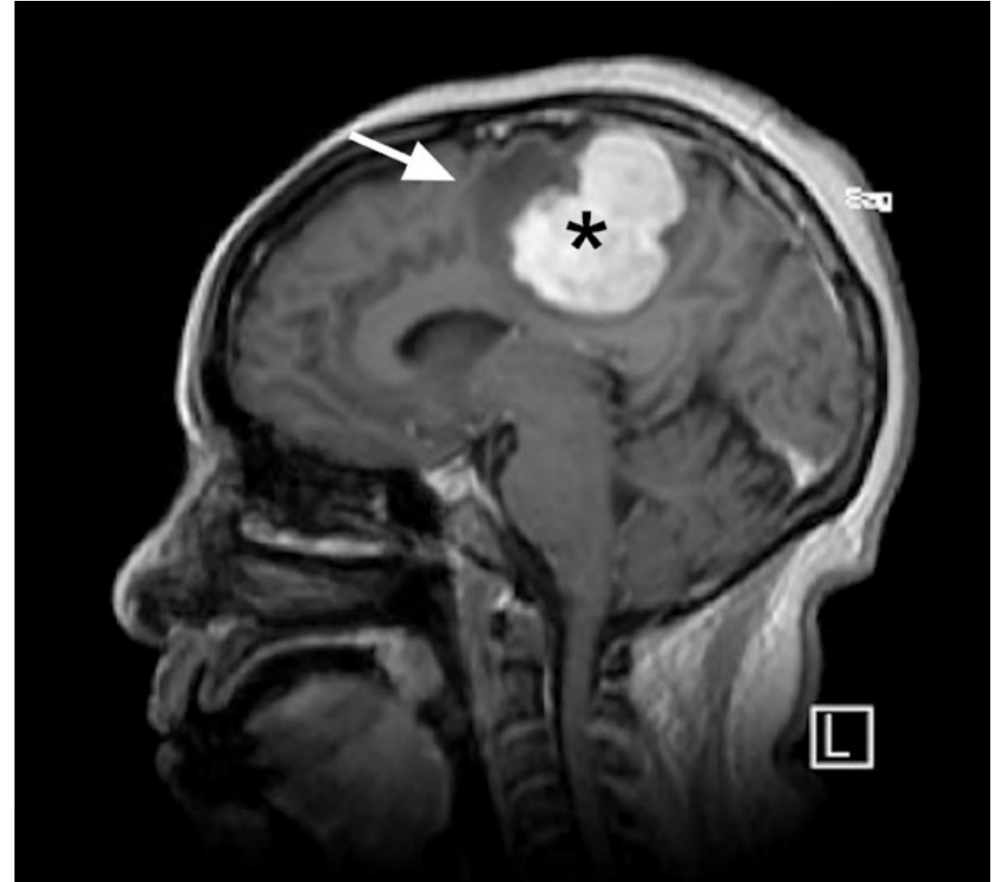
Magnetic resonance image shows a 4.3 × 3.8 × 4.3-cm, dural-based, left parafalx gadolinium-enhanced mass (asterisk) with surrounding edema (arrow) and mass effect.
